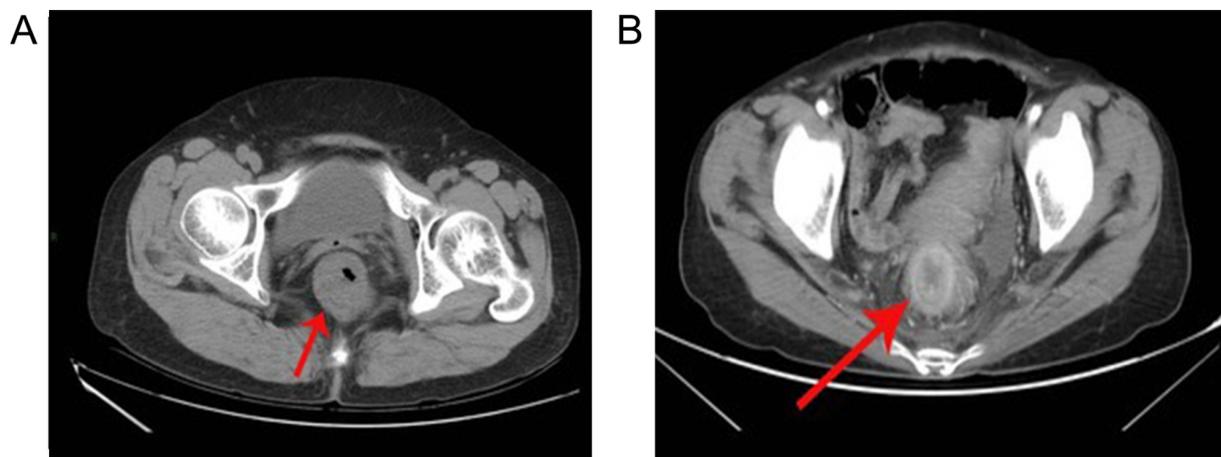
CT signs of rectal cancer. A: T4 stage disease determined via CT diagnosis; there are irregular thickening of the intestinal wall and stenosis of the intestinal lumen (arrow). B: Lesions break through the outer membrane of the intestinal wall (arrow), and the surrounding normal fat space disappears (arrow).
